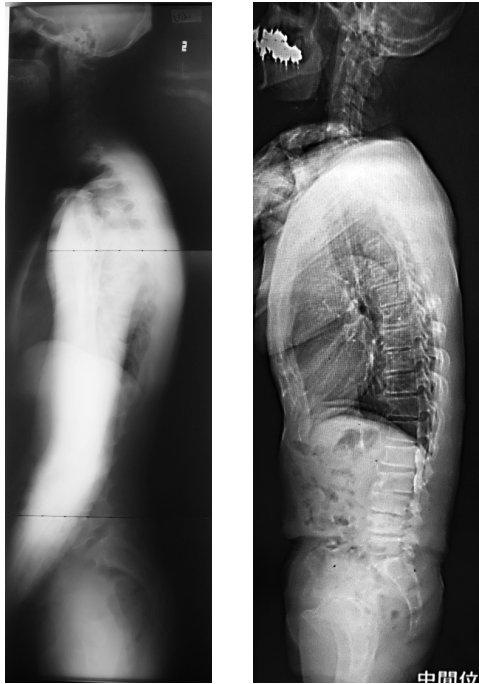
Left: Conventional radiography; Right: The SLOT radiography
